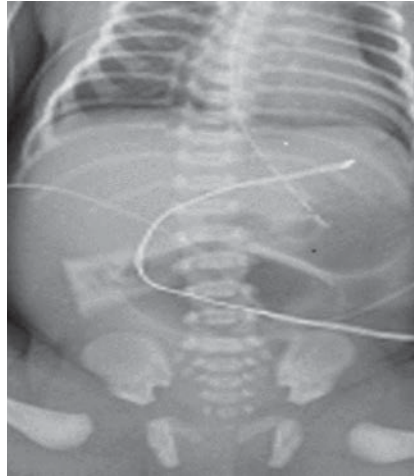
Abdominal radiograph performed at the end of the UGI series demonstrates moderately distended, contrast-filled proximal jejunal loops.
